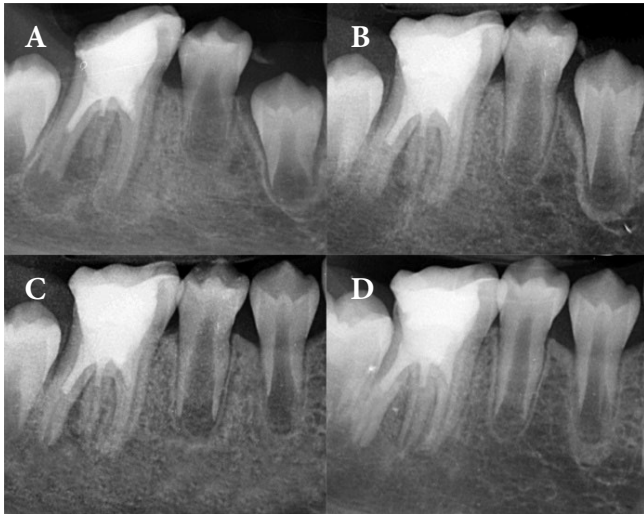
A) Immediate post-operative radiograph; B-D) Follow-up radiographs at 6-, 12-, and 15-months post-treatment, respectively, showing progressive healing of periapical radiolucency and improvement in root development
